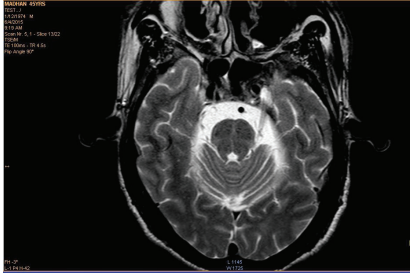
MRI Brain (T2W Axial) showing typical Hot Cross Bun appearance of Pons
